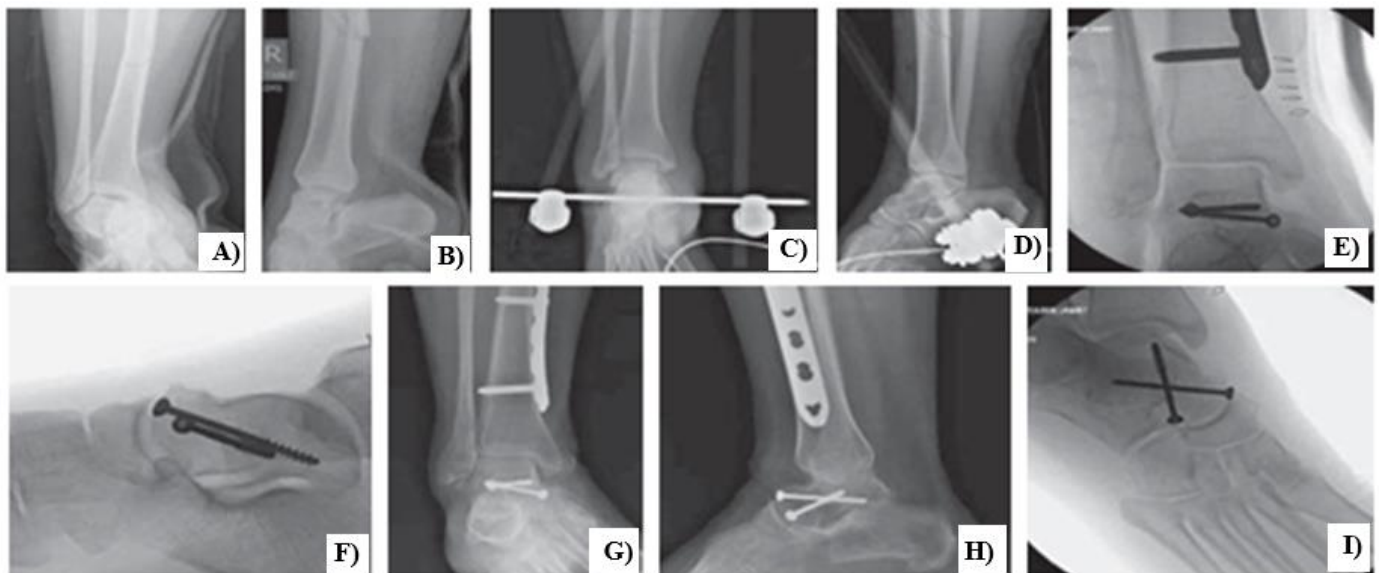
A 37-year-old woman sustained multiple injuries in an automobile vs train accident, including a displaced talar neck fracture with subtalar joint dislocation (A) and subluxation of the tibiotalar joint (B). Due to her multiple associated injuries, her talus fracture was initially treated by closed reduction (C) and application of a spanning external fixator (D). When her condition improved, she underwent open reduction and internal fixation using dual surgical approaches and 2 anterior to posterior lag screws (E-G). The patient has a good clinical and radiographic result 18 months after reconstruction (H, I).
